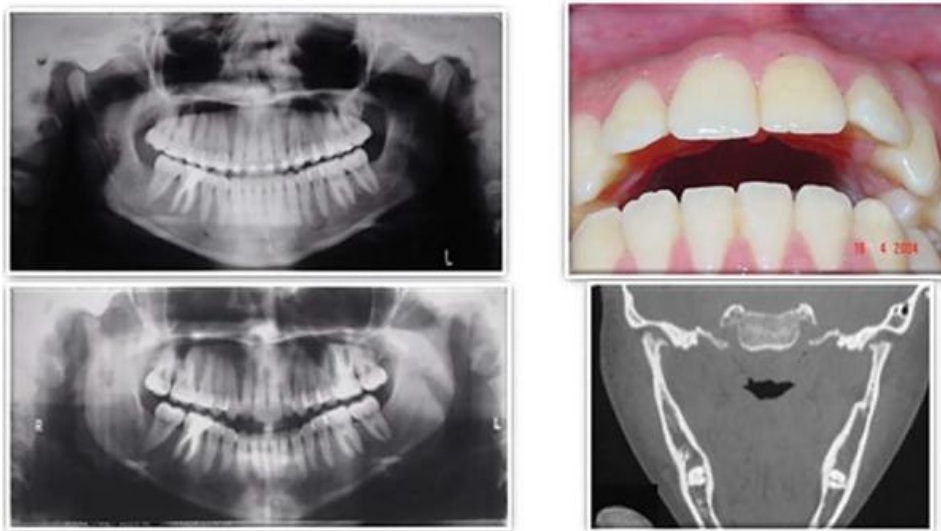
Anterior open bite secondary to rheumatoid arthritis radiographic and clinical images [14].
